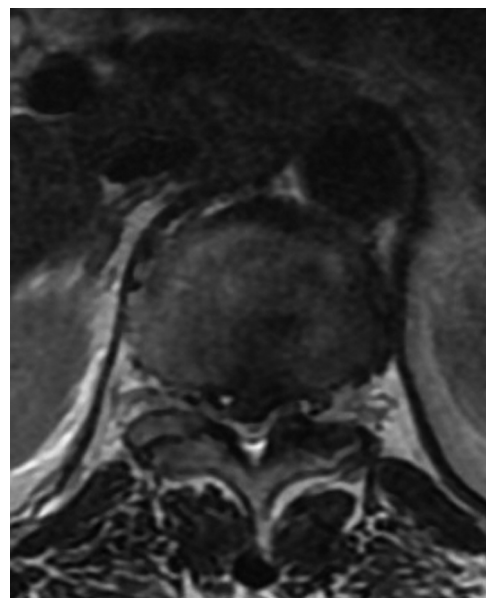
Preoperative axial T2-weighted (T2W) magnetic resonance imaging of a 46-year-old male patient with right paracentral T12/L1 disk herniation and cord compression.
